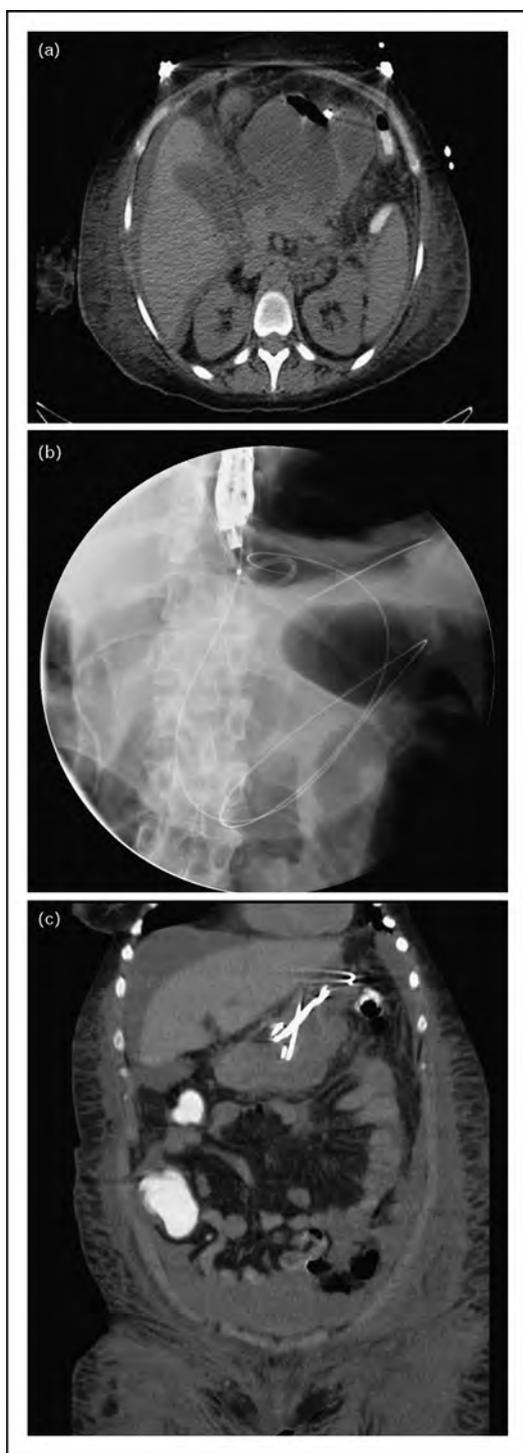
Endoscopic ultrasonography-guided drainage of walled-off pancreatic necrosis (WOPN) using multiple transluminal gateways technique (MTGT). (a) A computed tomography (CT) of the abdomen revealing a large WOPN. (b) Fluoroscopic image revealing passage of a guidewire into a different site (site #2) in the WOPN following initial placement of a transmural stent (site #1). (c) Following drainage by MTGT, CT of the abdomen at 72 h reveals marked resolution in size of the WOPN. The multiple stents are better visualized on coronal view.
